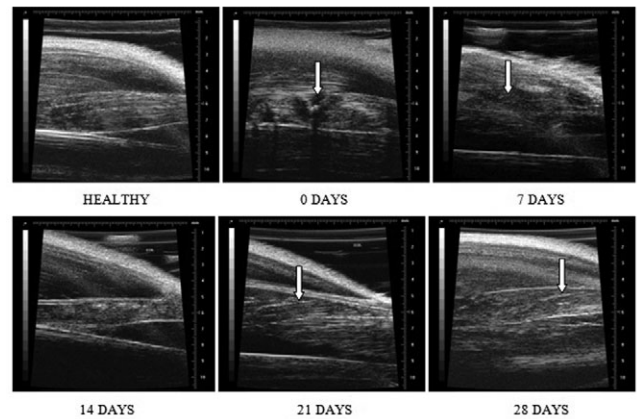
Sequence of ultrasonic images of the soleus of the right limb of *R. norvegicus* at the different intervals (before and after injury). Healthy: fascicles and aponeurosis intact, allowing the identification of PA and MT; 0 days (immediately after injury): tissue disorganization and disruption of the fascicles and aponeurosis, with hypoechoic areas (arrow) corresponding to hemorrhage and edema; 7 days: disorganized tissue, apparently loose fascicles (arrow) without connection to aponeurosis and discontinuity of superficial aponeurosis; 14 days: internal aponeurosis reorganized with discontinuation of the fascicles, which prevents measurements of PA and MT; 21 and 28 days: appearance of hyperechoic bundles (arrow) associated with fibroadipose connective scar tissue.
